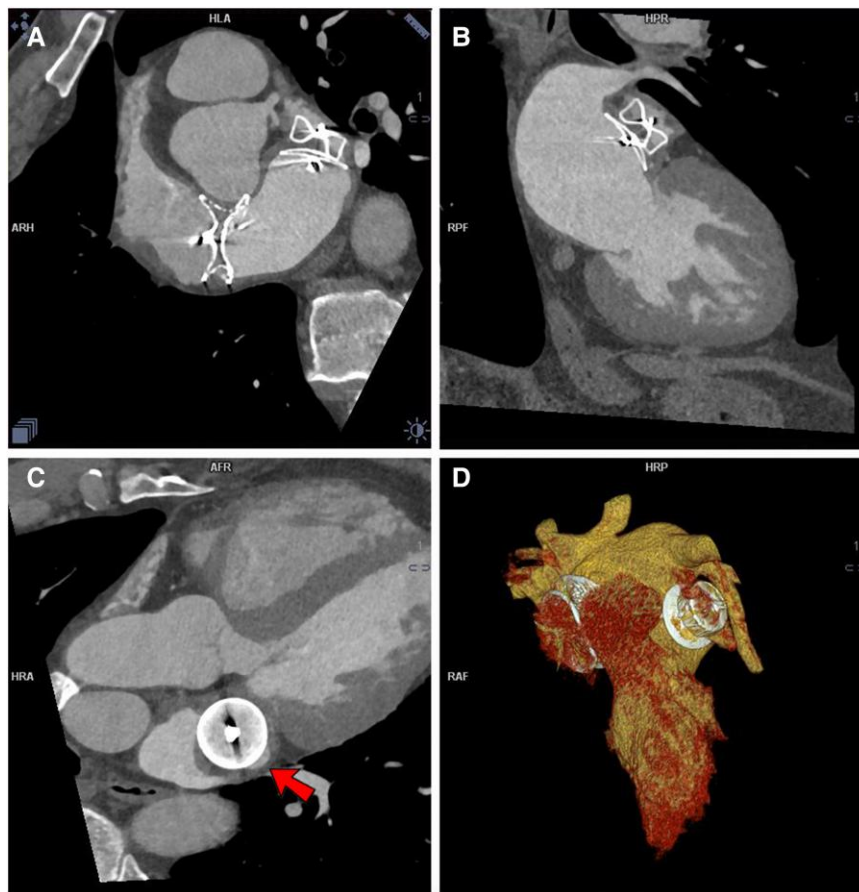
Follow-up cardiac computed tomography images. (A–C) show the corresponding orthogonal multiplanar reconstructions of the left atrial appendage, with (B) depicting a right anterior oblique 30° and cranial 10° view. (C) shows an en face view of the Amulet device disc, revealing a small peridevice gap at 5 o'clock (arrow). Contrast opacification can be visualized in (A) and (B) distal to the device lobe. (D) shows 3D images of the heart, with the Amplatzer Septal Occluder and left atrial appendage occlusion devices *in situ*.
